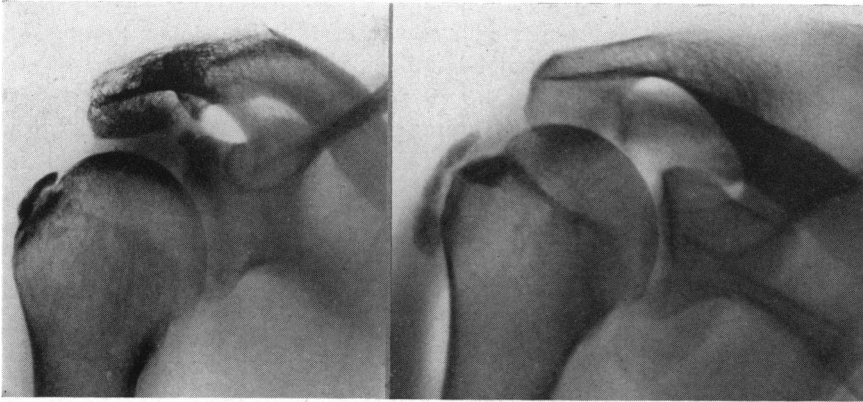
(A) Roentgenogram of patient in Fig. 2. (B) Roentgenogram of another similar case. Note typical position and relatively large area of calcium deposit in the acute bursitis with calcification.
